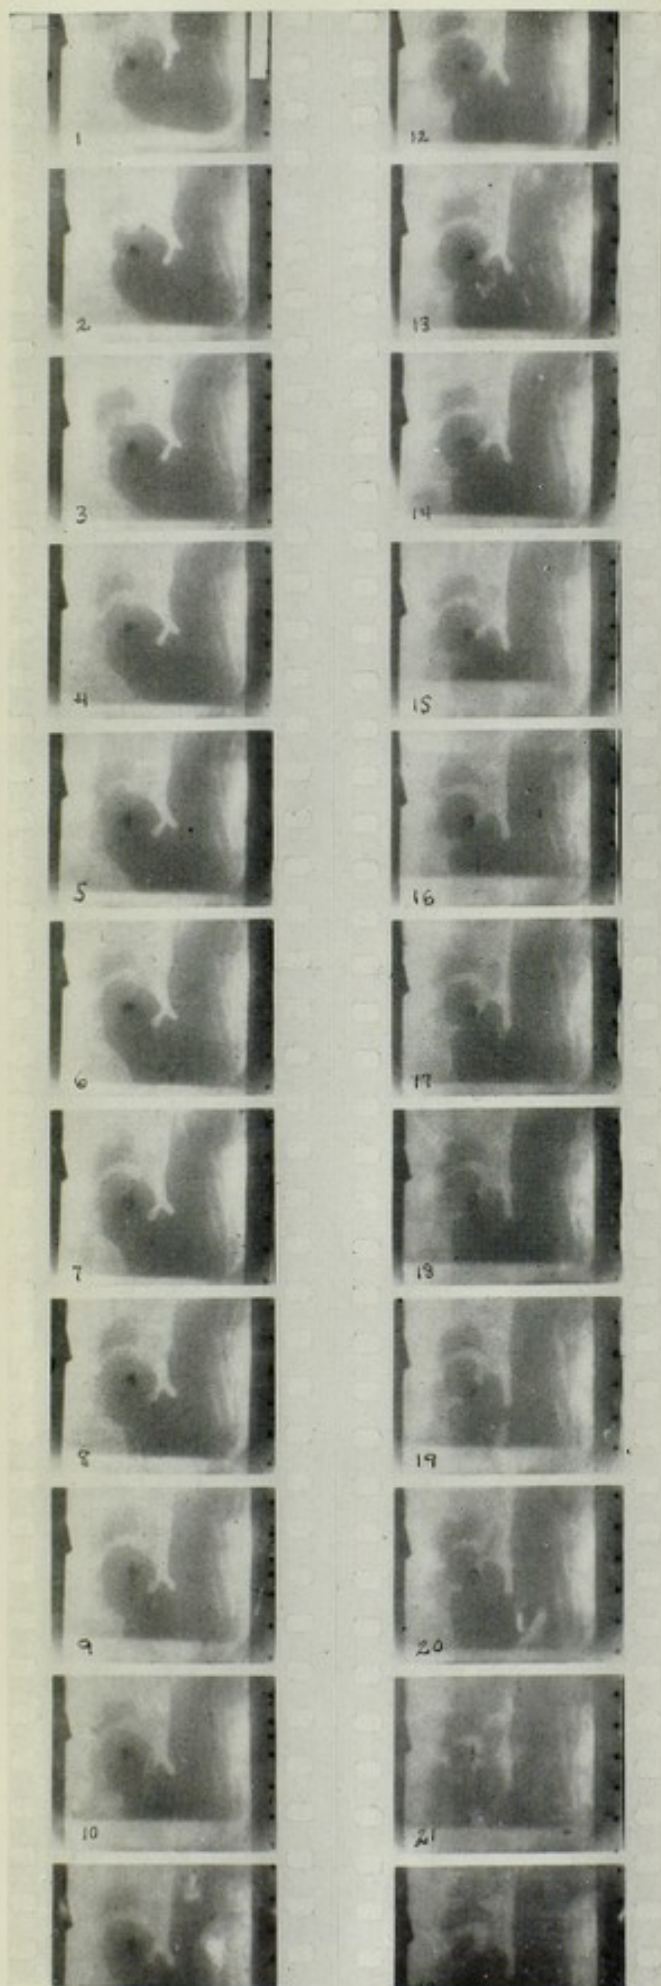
is the first Roentgenocinematographic film made with this apparatus. The 22 exposures were made in about 17 seconds. They show a nearly complete gastric cycle, or the formation and duration of a single antrum. The subject was one of my office assistants, a young woman free from gastric symptoms.
